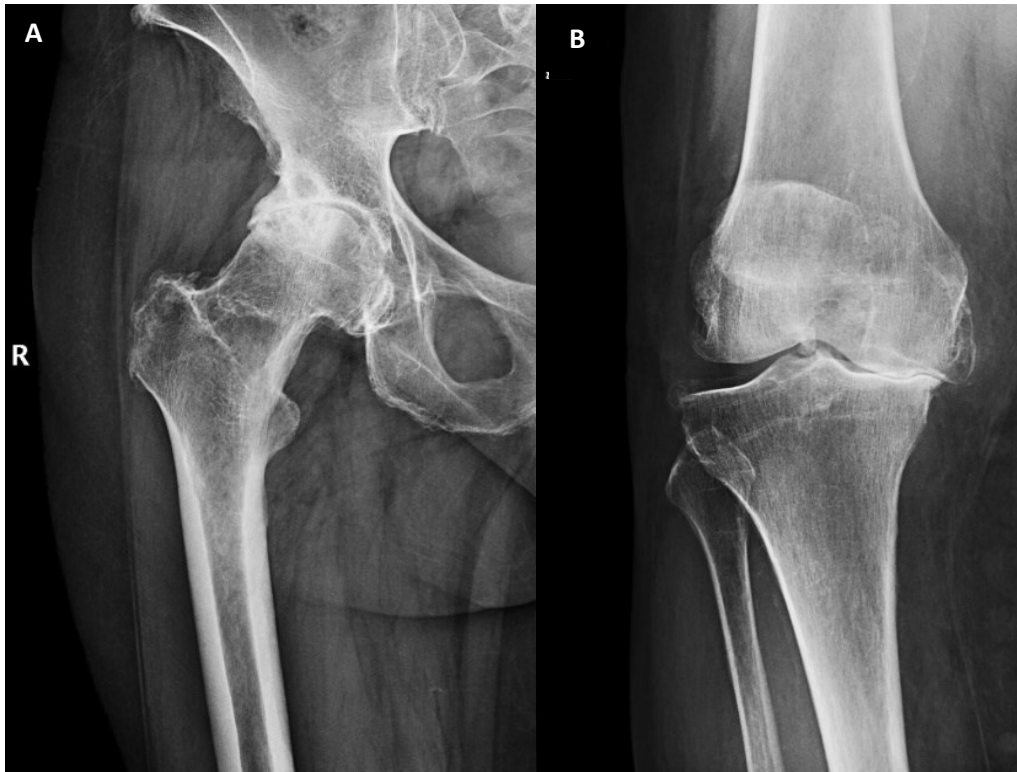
A – X-ray osteoarthritis of the hip grade 3
